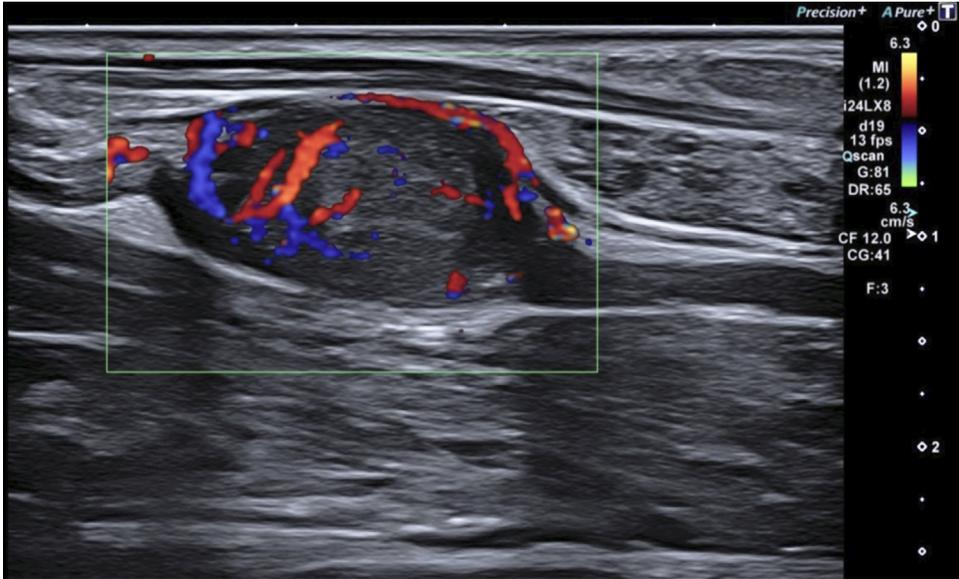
Median nerve proximal to the carpal tunnel inlet (long-axis view, Doppler-mode). Nerve sheath tumor (Schwannoma) with typical hypervascularity.
